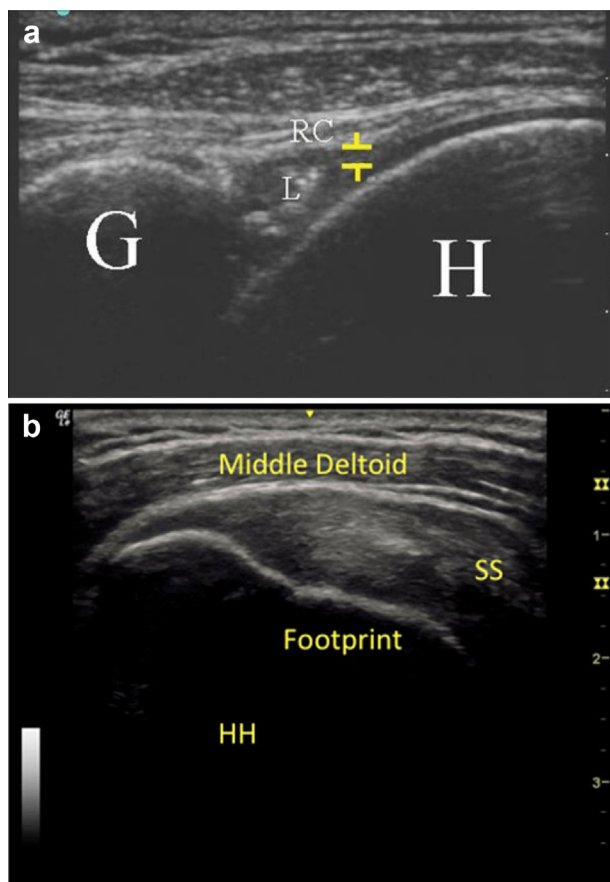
(a) Ultrasonographic image of posterior capsule thickness shows the calipers (yellow brackets, posterior capsule), the glenoid (G), humeral head (H), labrum (L), and the rotator cuff (RC). Reprint from Thomas et al.,³⁵ with permission from Elsevier. (b) Ultrasonographic image of longitudinal view of supraspinatus tendon (SS), middle deltoid, footprint, and humeral head (HH).
